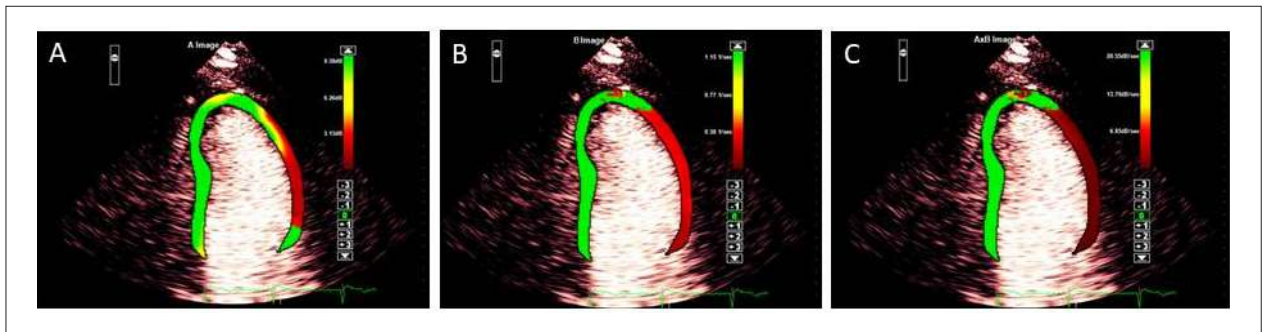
Example of offline myocardial perfusion analysis. Apical 2-chamber view of the LV. Note extensive perfusion deficit on the anterior wall (red). A, capillary blood volume analysis (α component). B, capillary blood velocity analysis (β component). C, microvascular blood flow analysis ($\alpha \times \beta$).
